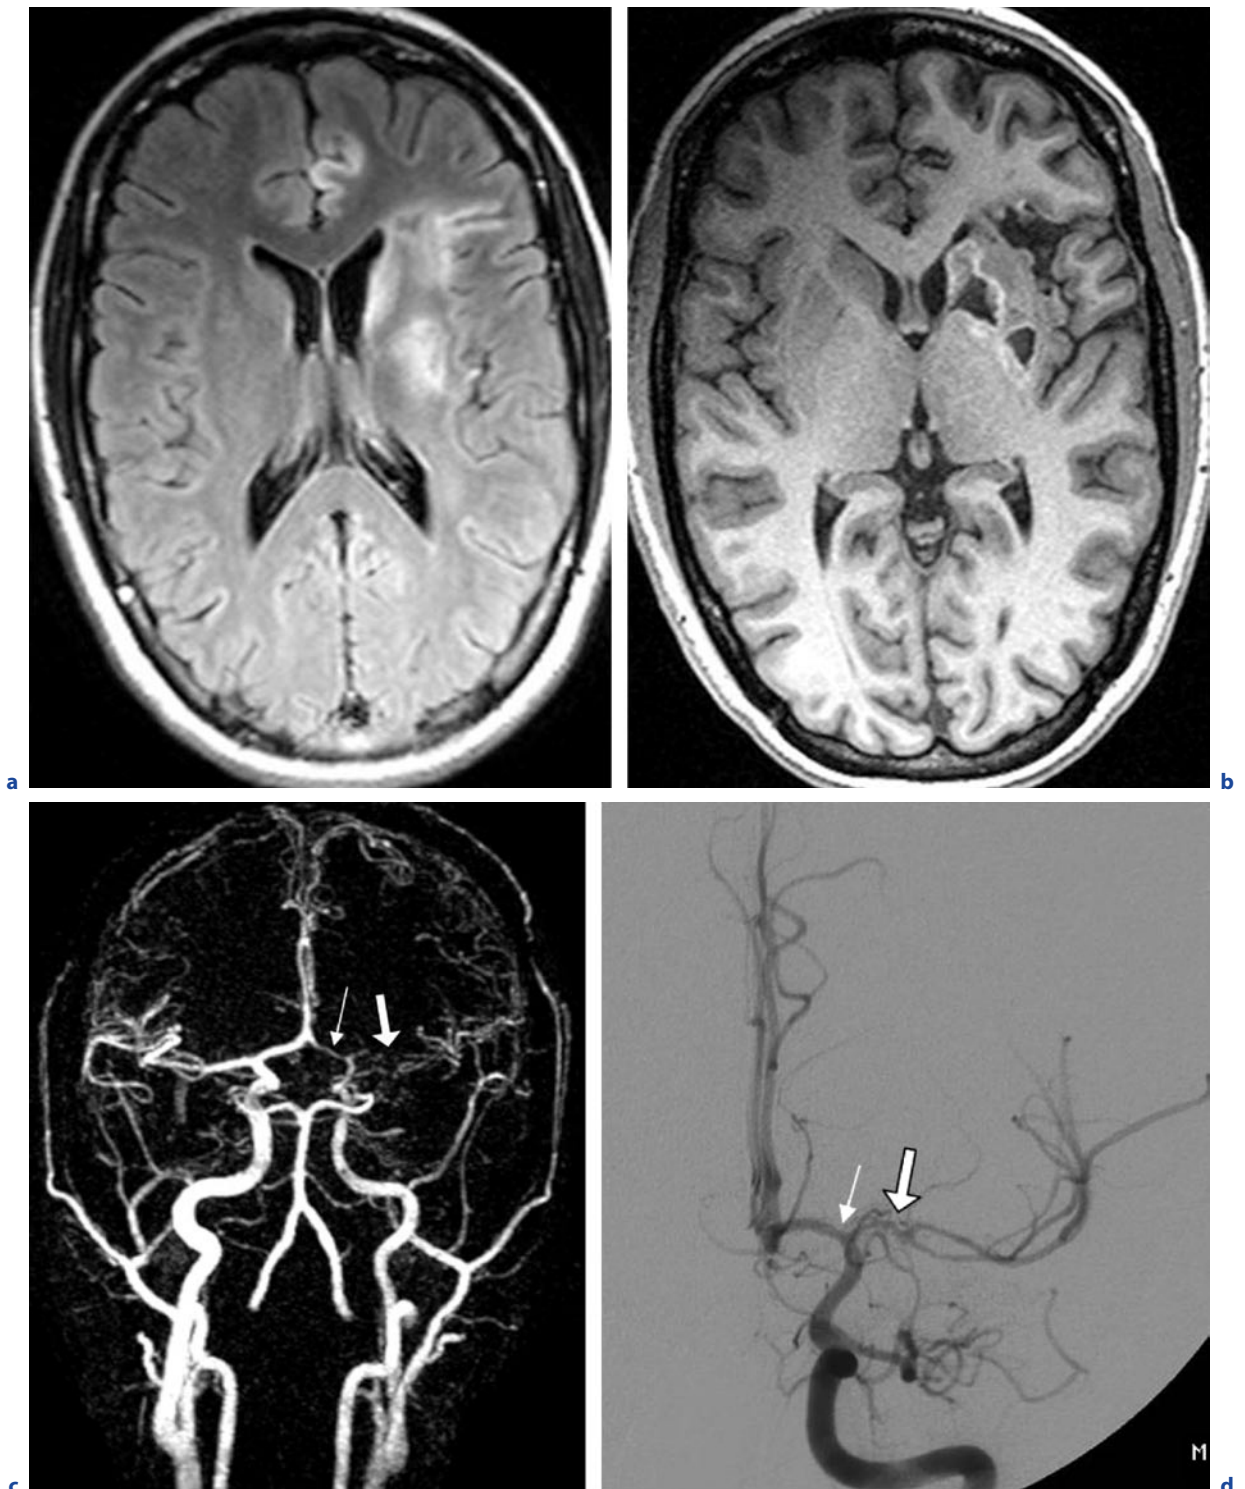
Spirochetal vasculitis (*Borrelia burgdorferi*). A 20-year-old woman with erythema migrans, bilateral headaches, and recurring cramps in the right hand. a Axial FLAIR image. b Axial T1-weighted image. c MIP of a arterial TOF MRA. d DSA of the left ICA, frontal view. Left-hemispheric hyperintensities mainly affecting cortical and subcortical gray
